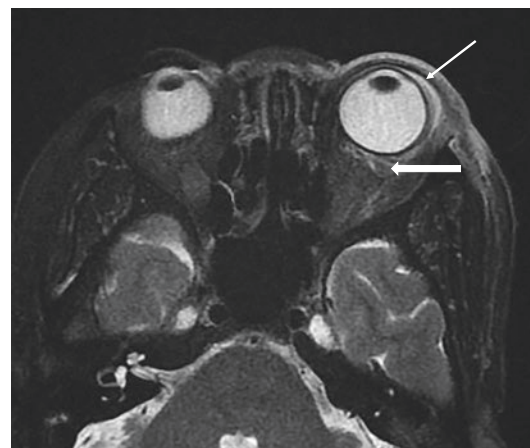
Axial fat saturated T2 weighted MRI showing fluid in the pre-septal periorbital tissues (thin white arrow) and fat stranding in the retrobulbar post-septal intraconal space (thick white arrow)
